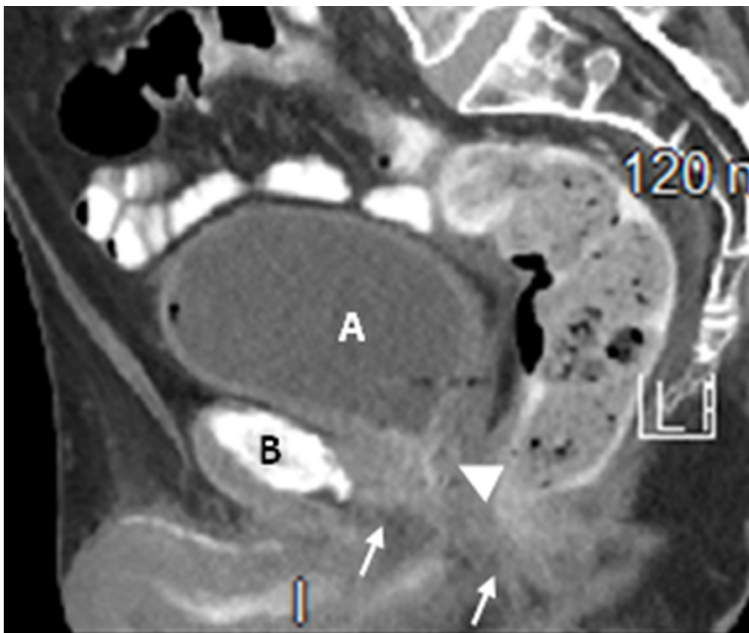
Sagittal CT image through the pelvis with oral and IV contrast shows the bladder (A) and inflammatory change in the vicinity of the posterior urethra (arrowhead) with fistulas (arrows) extending anteriorly towards the pubic bone (B) as well as posteriorly towards the perineum/gluteal region.
